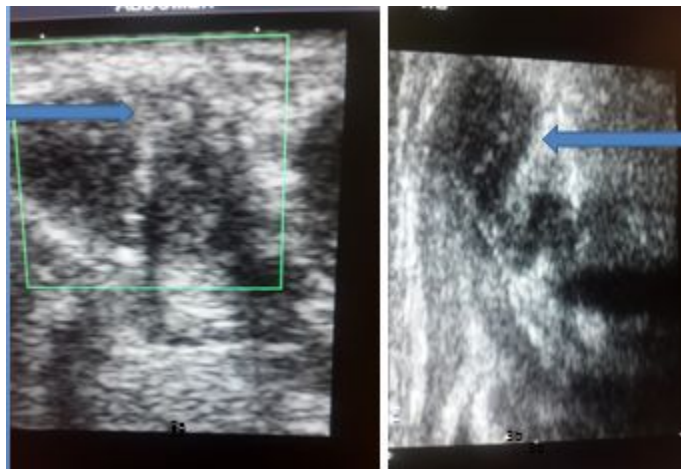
Ultrasound and color Doppler of the neck region. (a) axial and (b) sagittal images. Hyper echoic structure with distal shadowing seen in both views (arrows). No vascularity was noticed in the surrounding region.
